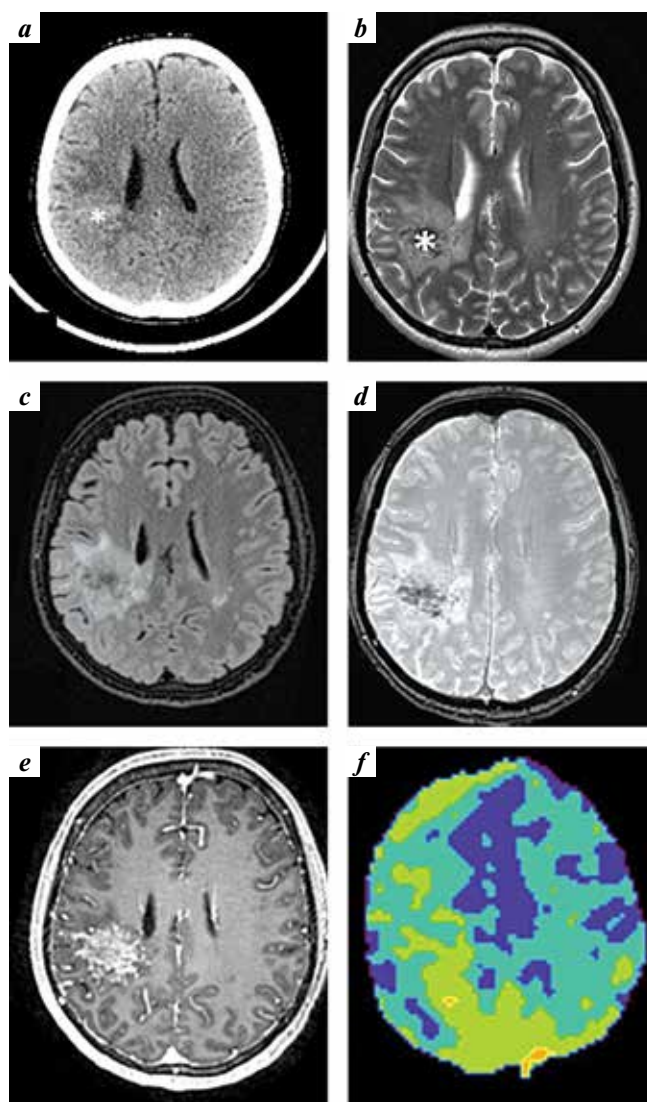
Clinical case 1. Brain computed tomography (a) and magnetic resonance imaging (b–f) of patient of 2023: an area (marked with a star) of an altered signal with indistinct boundaries in the deep area of the right parietal lobe, surrounded by minimal perifocal edema (a) hyperintense on T2 (b) and FLAIR (c) with multiple small hemorrhages on the SWAN sequence (d); with heterogeneous accumulation of contrast agent (e) as well as slight increase of T_{max} during cerebral perfusion examination (f)
